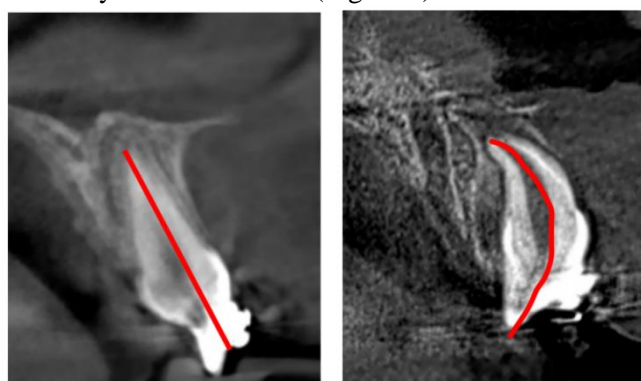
CBCT images revealing a stark difference between the two maxillary central incisors with clear dilaceration in left maxillary incisor (figure 8 a,b)
